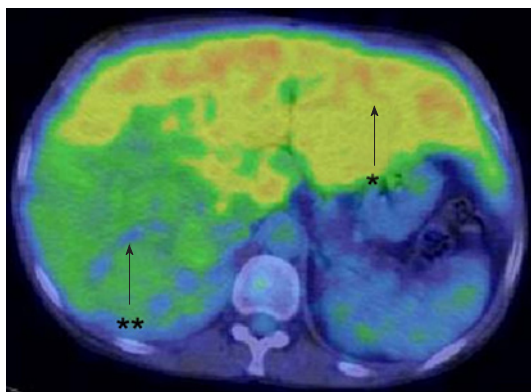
Fluorodeoxyglucose-positron emission tomography/computer tomography. High levels of FDG accumulation with a SUVmax of 4.2 in the non-tumorous liver (arrow, star) and relatively low uptake of FDG with a SUVmax of 2.7 in the tumor (arrow, double star). FDG: Fluorodeoxyglucose-positron emission tomography.
